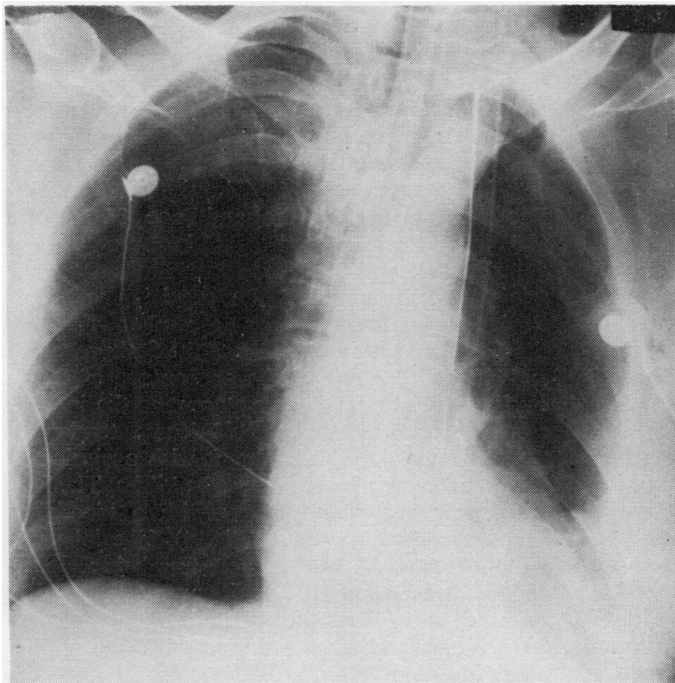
Immediate postoperative chest radiograph showing good expansion of the left lower lobe.*
